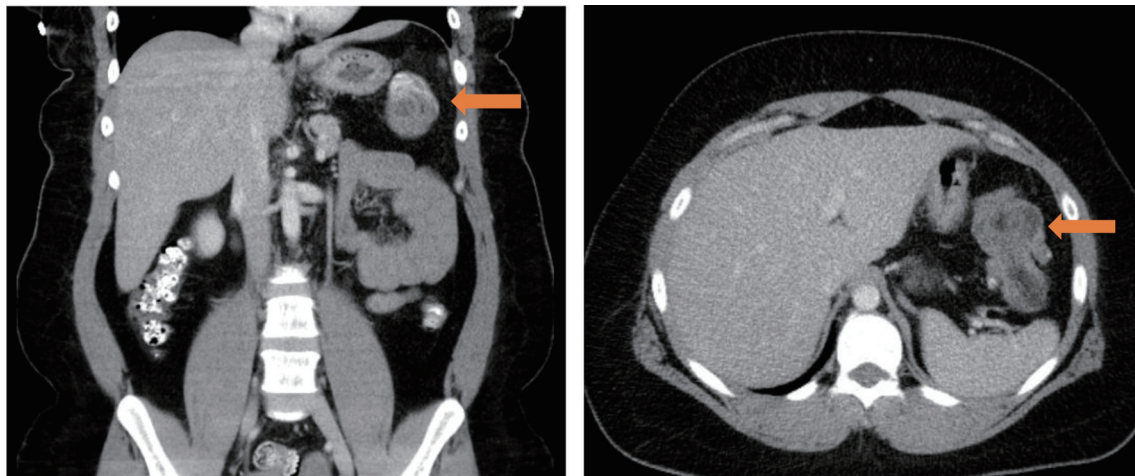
Initial computed tomography (CT) of abdomen/pelvis, coronal view (a), axial view (b), demonstrating splenic flexure colocolic intussusception with a lead point.
